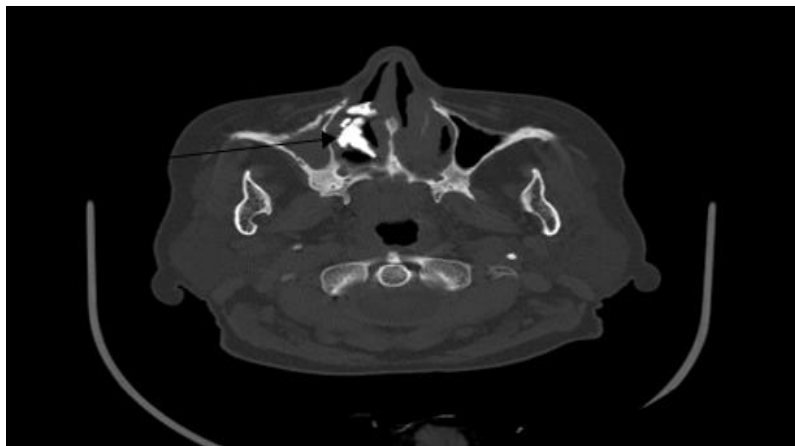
Axial naso-sinusal CT scan showing rhinolithiasis opposite the middle meatus (black arrow) responsible for mucosal filling of the right maxillary sinus
